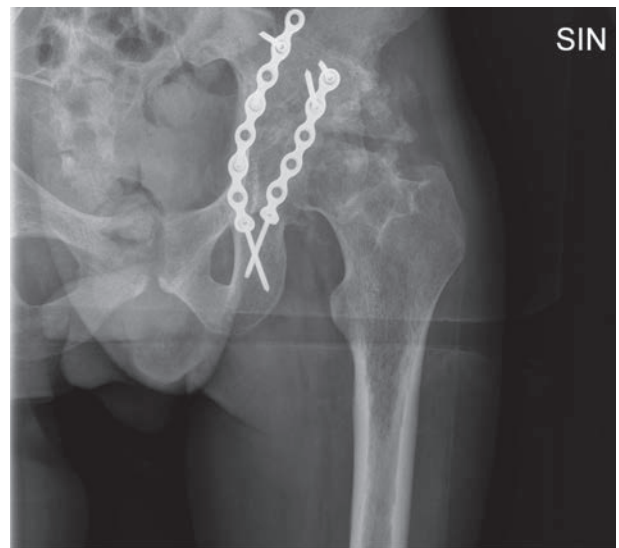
Six months follow up x-rays
